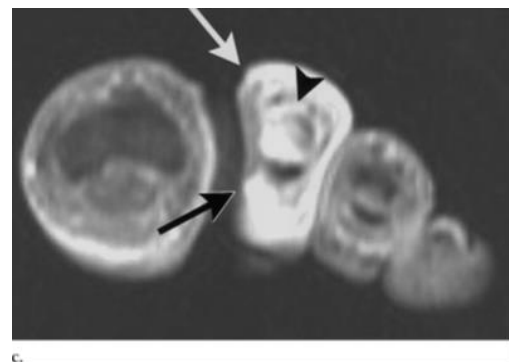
Coronal T1-weighted fat-suppressed scan with IV contrast
